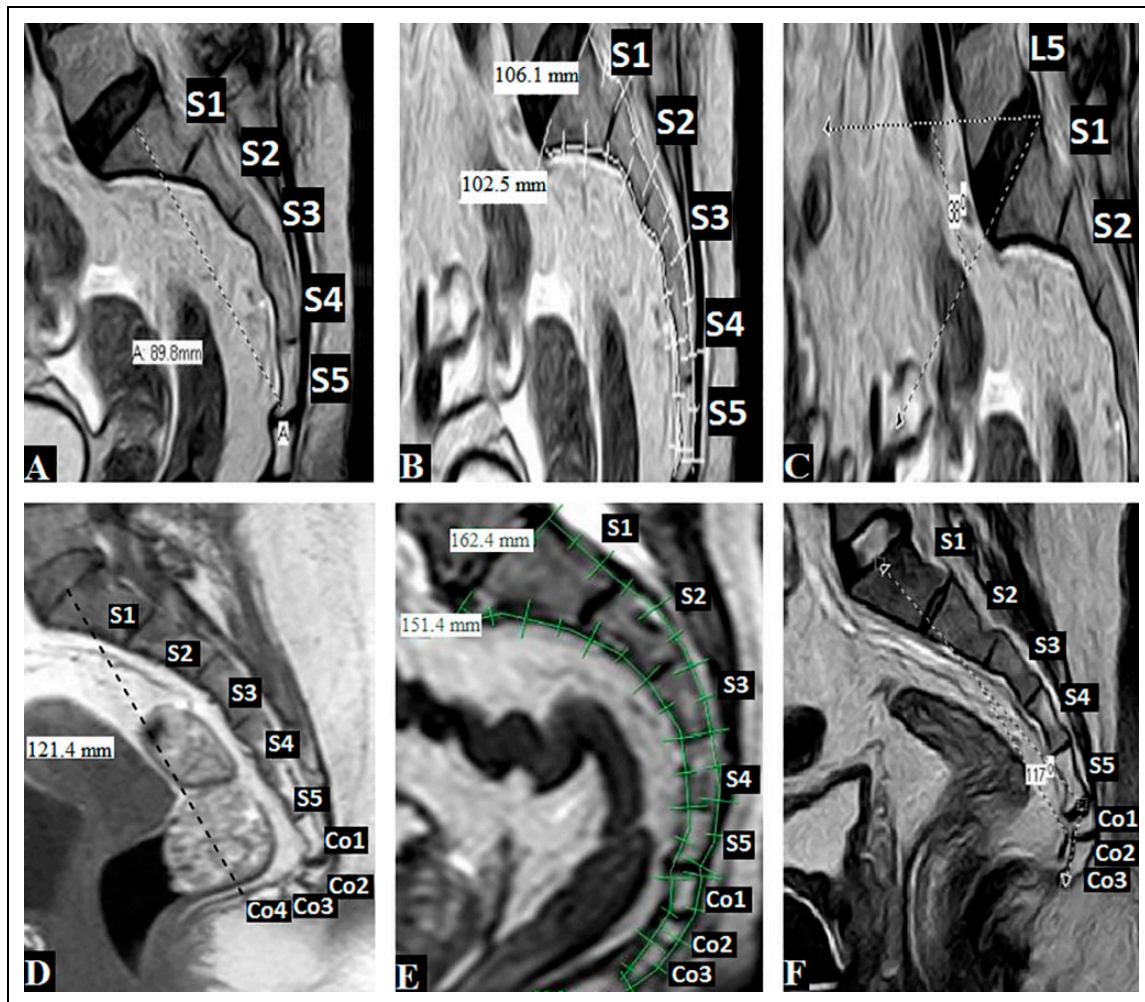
MRI of the sacrococcygeal region showing: (A) Sacral straight length: Length of a straight line from the middle of the upper border of S1 to the middle of the inferior border of S5. (B) Sacral curved length: Average of the anterior and posterior curved sacral lengths measured from the upper border of S1 to the inferior border of S5. (C) Sacral angle: Angle between a straight line along the upper border of S1 and the true horizontal line. (D) Sacrococcygeal straight length: Length of a straight line from the middle of the upper border of S1 to the coccygeal tip. (E) Sacrococcygeal curved length: Average of the anterior and posterior curved sacrococcygeal lengths measured from the upper border of S1 to the coccygeal tip. (F) Sacrococcygeal angle: Angle between a line from the midpoint of the upper border of S1 to the midpoint of the upper border of Co1 and a line from the latter to the coccygeal tip.
